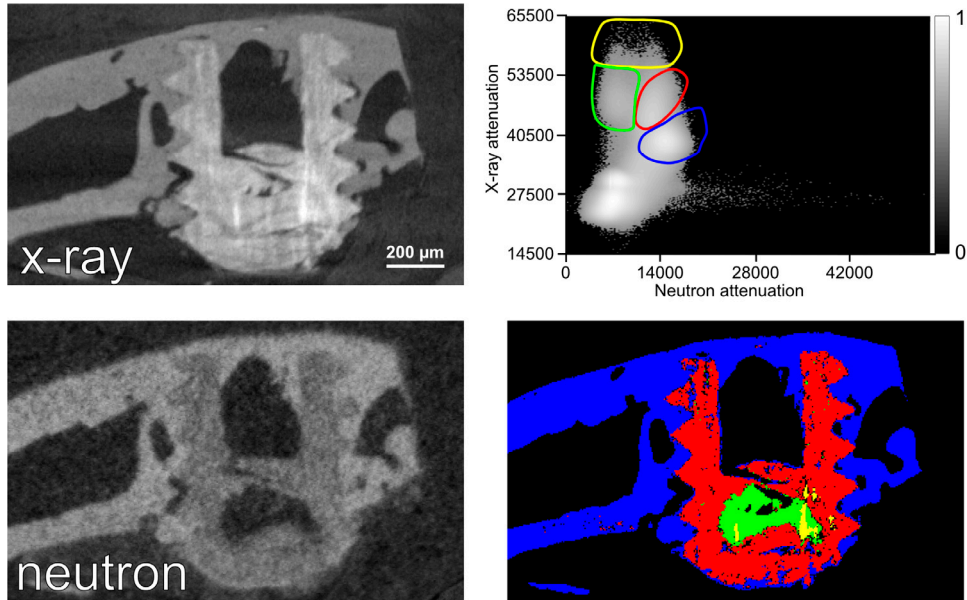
Bimodal analysis of x-ray μ CT and neutron μ CT by using the bivariate histogram.
